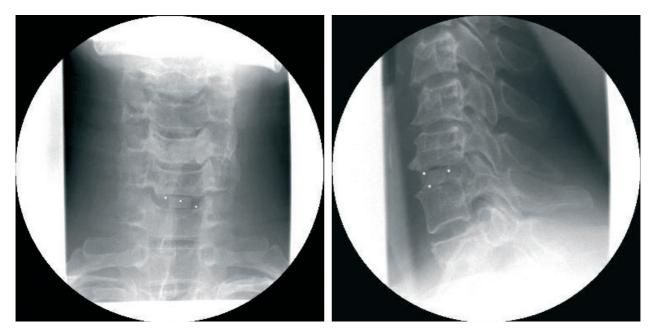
Examples of postoperative x-ray of porous HA bone substitute in block form as filler for an intersomatic cervical cage.
